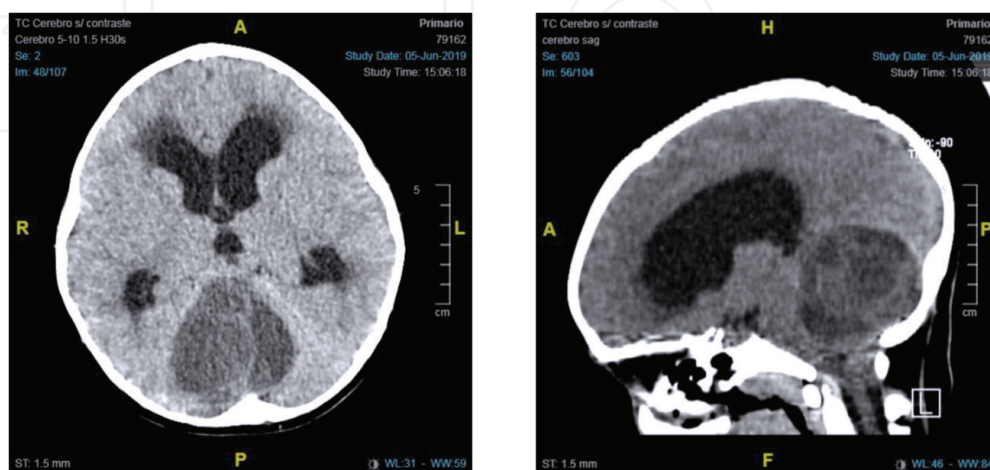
Head CT scan examination (A) axial section and (B) sagittal section demonstrated an inhomogeneous hyperdense lesion in the posterior fossa.
